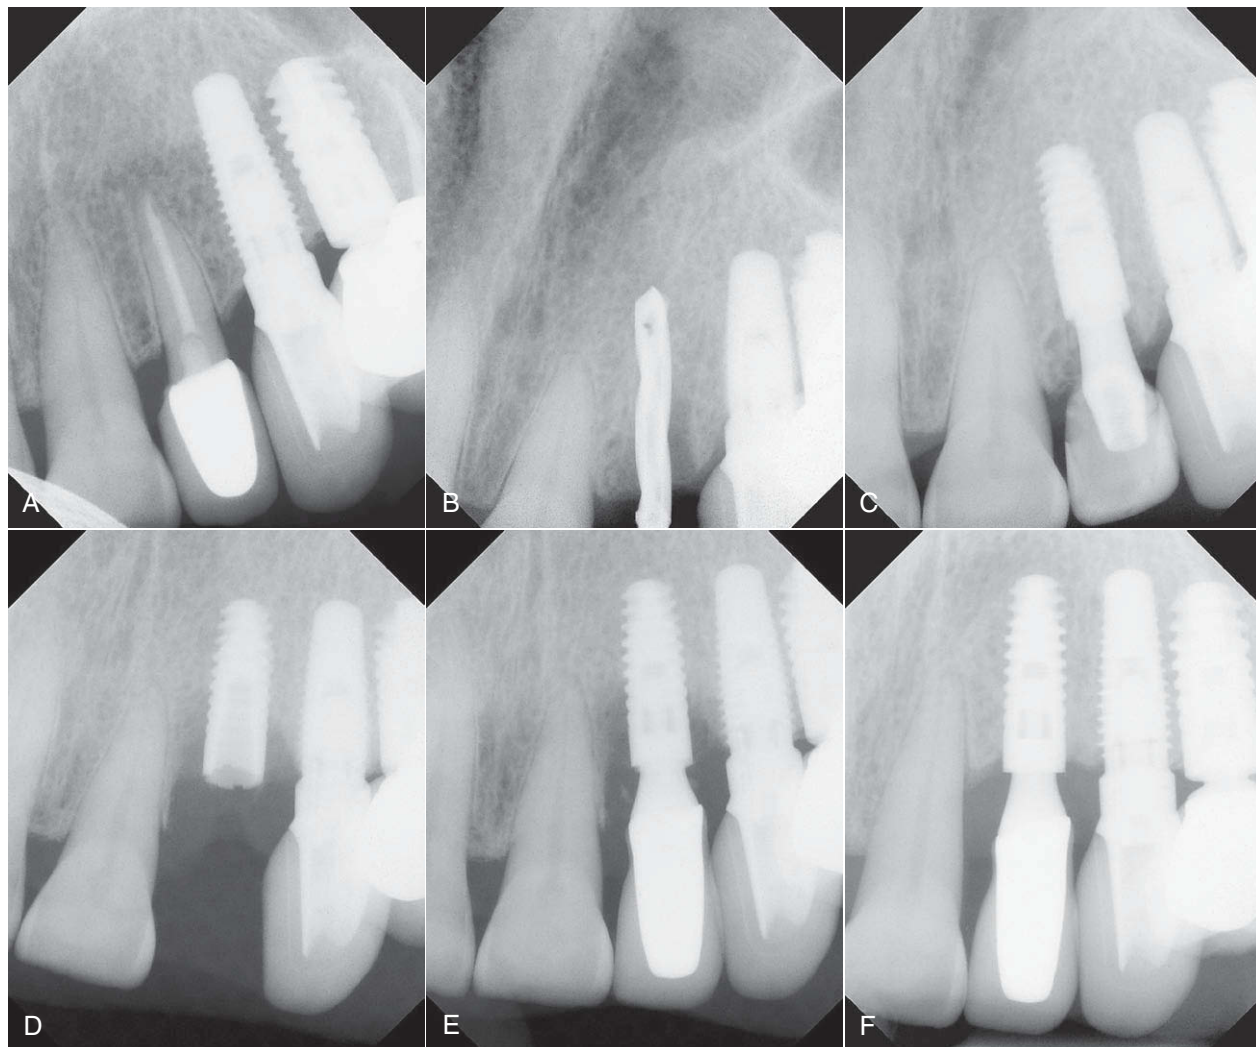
• A, Pretreatment radiograph of upper left lateral incisor to be extracted. B, Radiograph showing implant site being prepared immediately after extraction. C, Radiograph of immediately placed implant loaded with temporary crown. D, Bone loss to fourth thread. E, Radiograph at 1 month after treatments. F, Radiograph at 10 months after cementation. Bone has regenerated to within 1 mm of top of implant. No flap was raised and no grafting performed.
